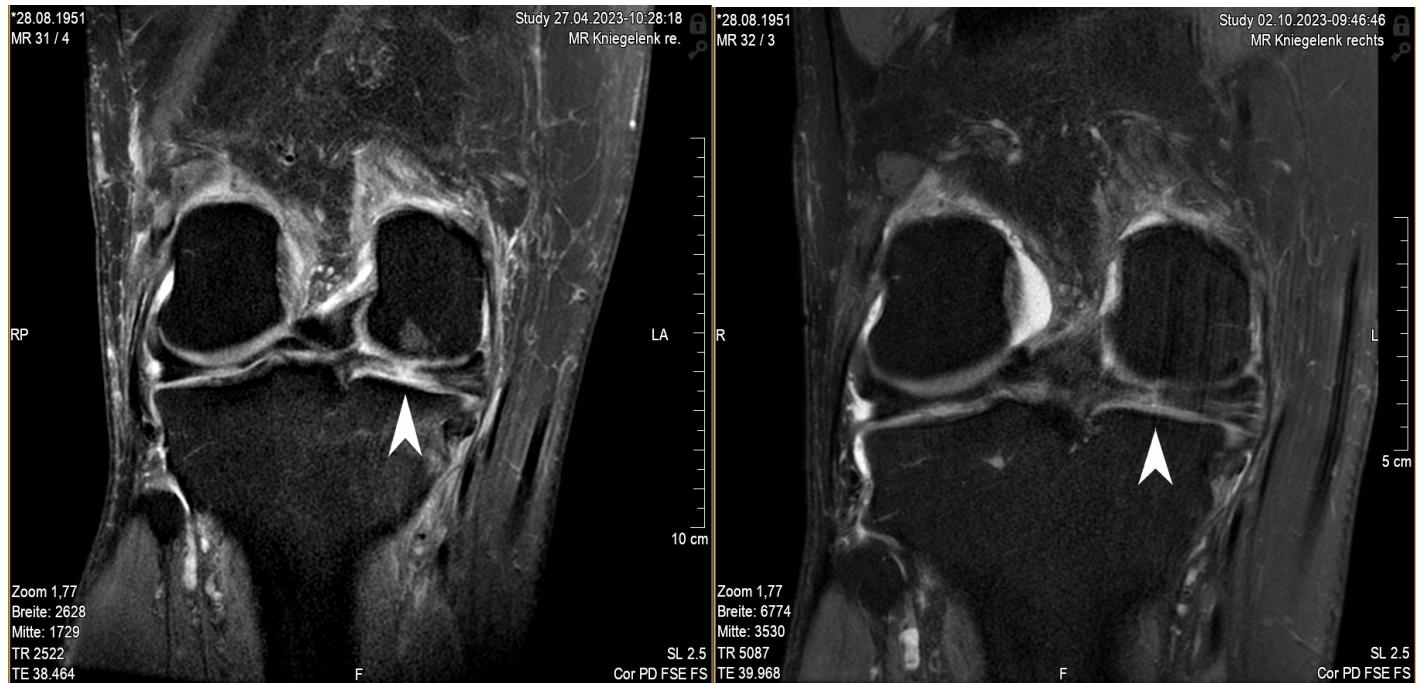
MRI before treatment with ciMSC EVs on 04-27-2023 (a): Large tear gap (arrow) along with bone edema and effusion. (b) MRI 10 weeks after treatment with ciMSC EVs on 10-02-2023: Improvement in various domains. Small radial meniscal tear gap scar (arrow), restored meniscal continuity, eliminated bone edema in tibia head and condyles, reduced peripatellar effusion, and greatly reduced size of Baker cyst (almost vanished).
